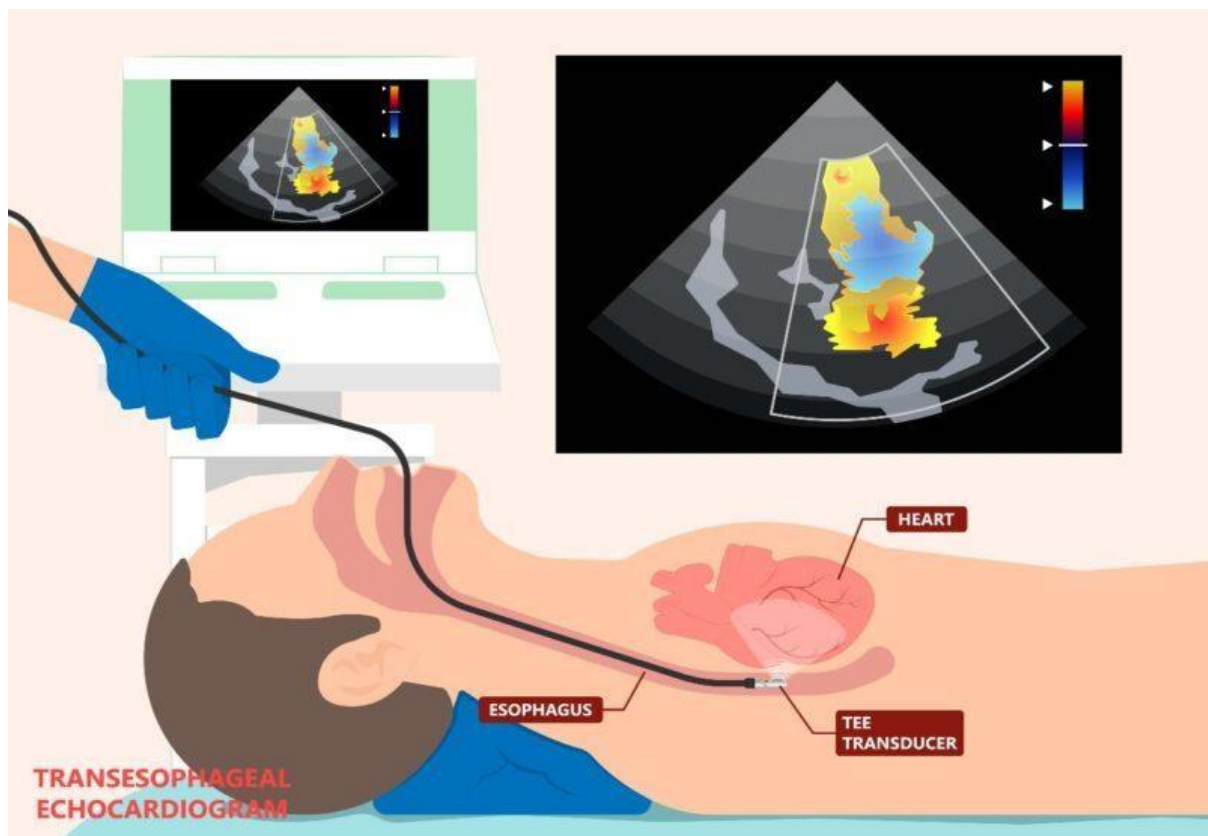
Transesophageal Echocardiography TEE [9].
